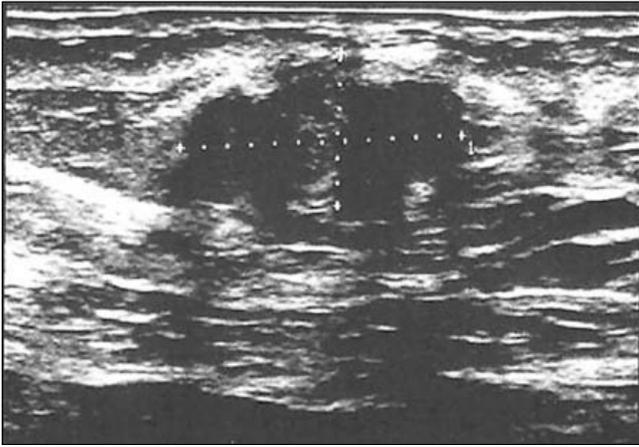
Preoperative ultrasonography in superficial soft tissue mass
